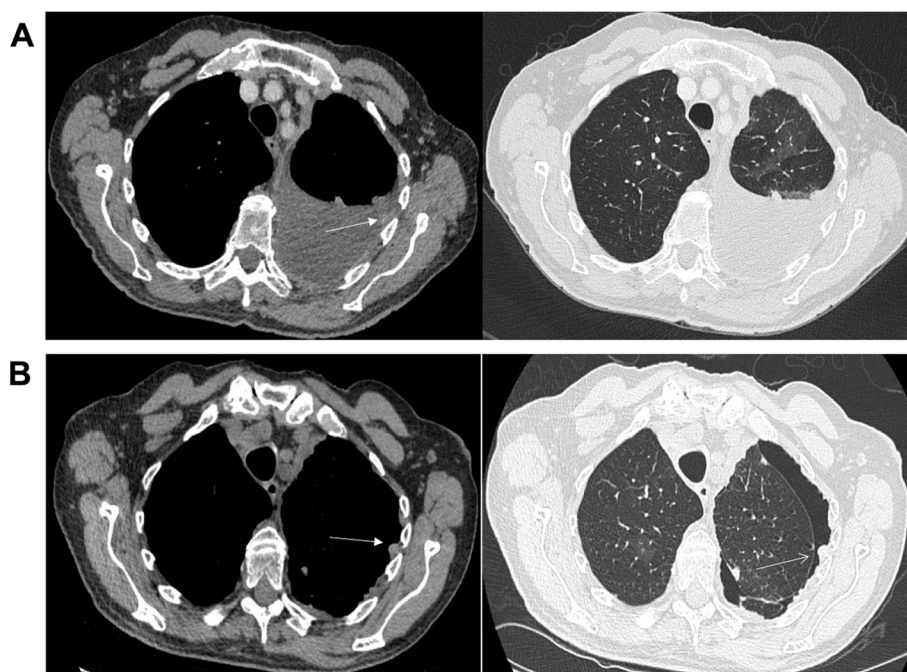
A, Axial CT imaging of the thorax above the aortic arch, showing a large left-sided pleural effusion with possible parietal pleural thickening (See arrow. mediastinal and lung windows included for comparison purposes with B). B, Postaspiration pneumothorax (visible on lung windows, right) reveals marked nodular parietal pleural thickening with possible sites for biopsy shown (arrows).
